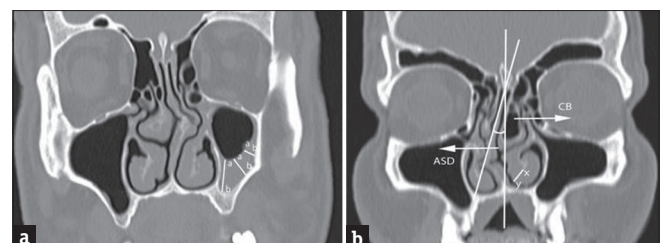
Coronal computed tomography image of a 50-year-old man who has left maxillary sinusitis. a-b length shows the measurement of the mucosal thickness on maxillary sinus. (a) Coronal computed tomography image shows a 44-year-old woman who has left concha bullosa, the measurement of medial mucosal thickness of the inferior turbinate (XY length) and the angle of septal deviation (b)
